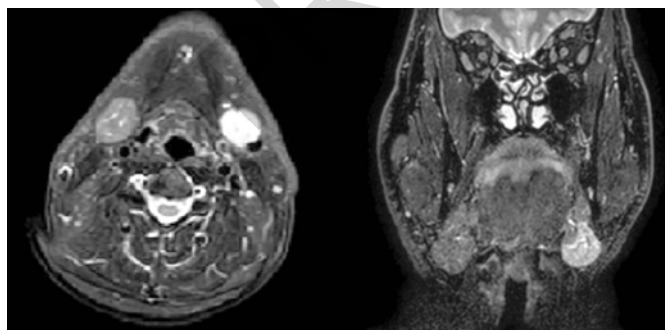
Magnetic Resonance Imaging: Axial and coronal T2-weighted images, respectively, showing a heterogeneous hyperintense mass with clear margins in the sub-mandibular gland.
